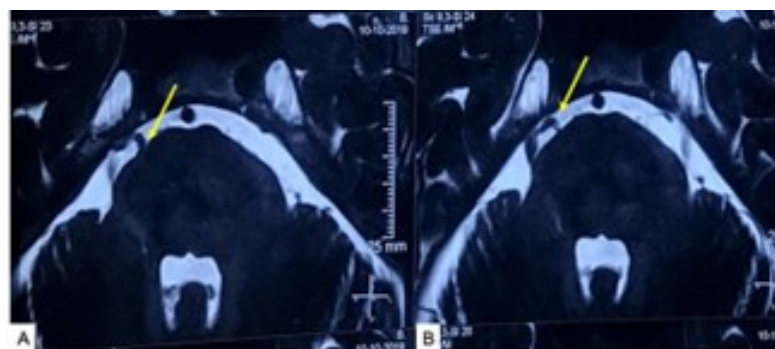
MRI in the TN protocol images (A,B) showing an artery at the REZ of the right trigeminal nerve causing neuralgia. Source: Figure by authors.
